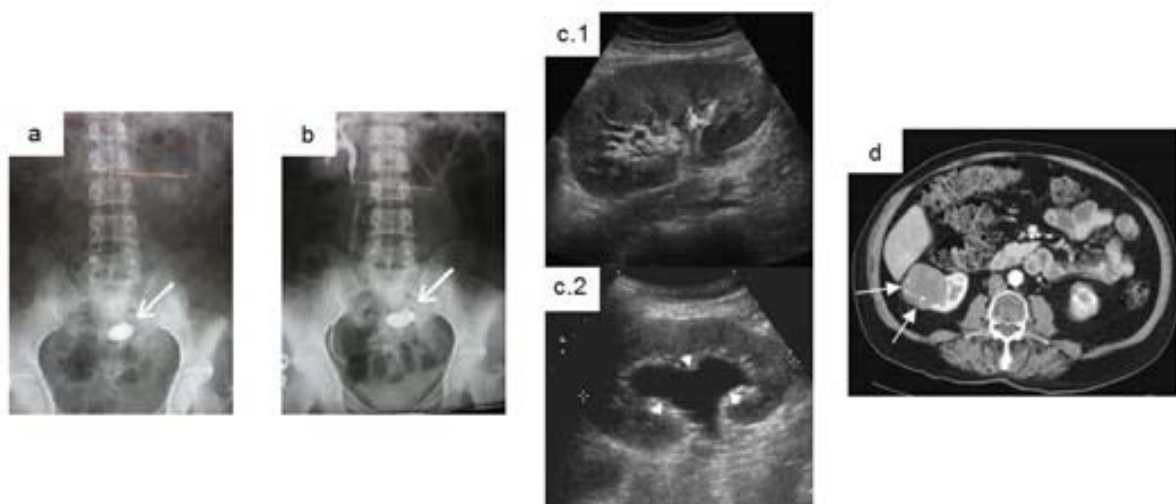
Typical images for the detection of stones. a. X-Ray image, the arrow points a bladder stone 30. b. X-Ray image after a IVU has been done (same patient as a) 30. c.1. Normal appearance of a healthy kidney. c.2. Kidney showing dilatation due to ureteral obstruction 28. d. CT scan of a patient, the white arrows show solid masses in the kidney 28.
